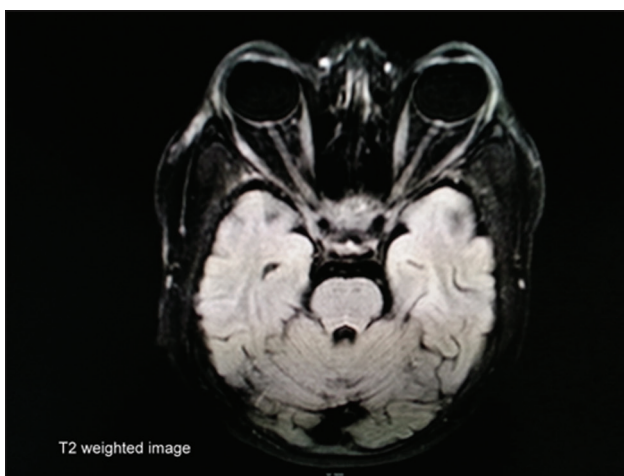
Magnetic resonance imaging T2 W imaging
